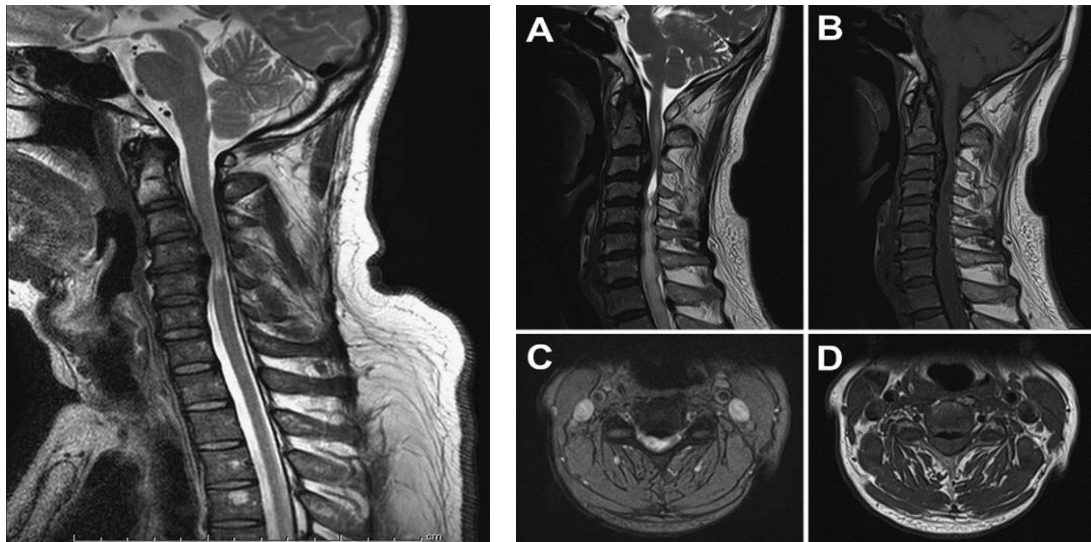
Figure # 1.1 A 45-year-old male presented with progressive neck pain, upper limb weakness, and sensory deficits. MRI of the cervical spine revealed ossification of the posterior longitudinal ligament (OPLL) from C2 to C6, causing significant spinal cord compression and syringomyelia at the C3-C4 levels. Axial imaging also identified a suspicious intramedullary lesion at the C4 level, showing T2 hyperintensity and T1 isointensity, suggesting a potential intramedullary tumor, likely a glioma or ependymoma.[28].
